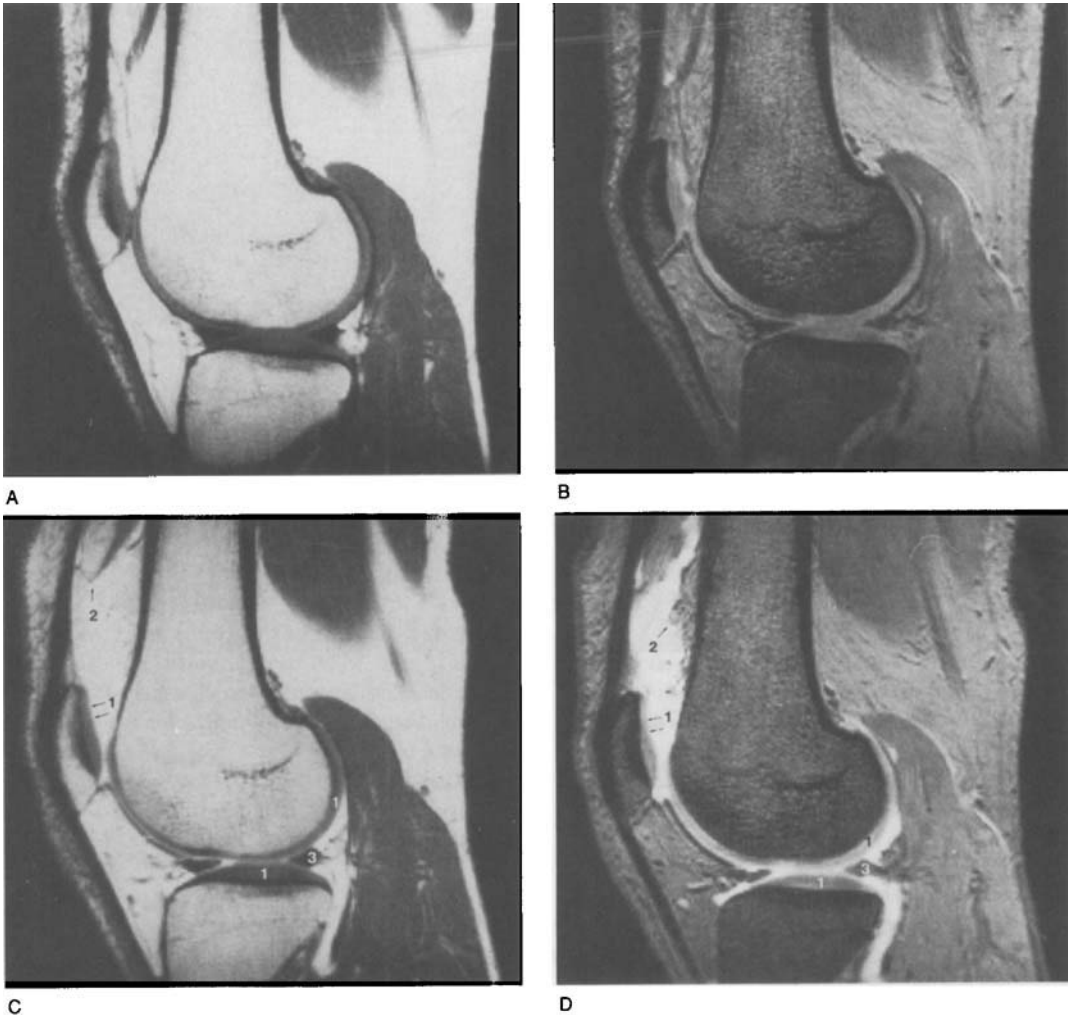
Normal hyaline articular cartilage. MRI, SE 700/15 (A and C), GE 300/10/30°, FISP-3D (B and D), normal knee joint, sagittal plane, immediately lateral to the medians.
